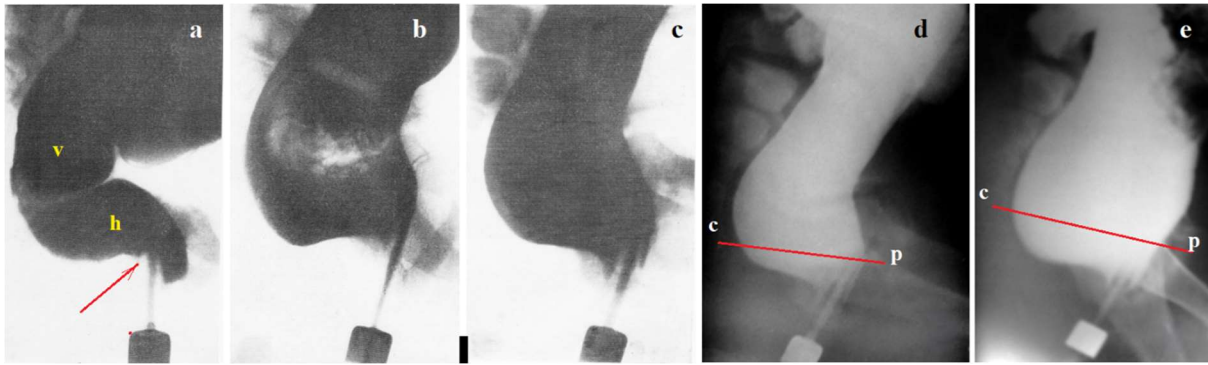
Lateral radiographs of the anorectal area in normal conditions (a) and with FM (b-e). (a) Two branches of the rectum are identified: vertical (v) and horizontal (h). The length of the anal canal is measured from the anorectal angle (arrow) to the radiopaque marker located near the anus. In the upper part of the anal canal in front of the enema tip, penetration of barium is determined, which is due to relaxation of the internal anal sphincter (IAS). The posterior wall of the anal canal at this level is pressed against the tip of the enema by the contracted PRM. The lower part of the anal canal is closed by contraction of the external anal sphincter (EAS). This is a retention reaction, which is the radiological manifestation of the rectoanal inhibitory reflex [15]. (b-c). Dilatation of the rectum is accompanied by the disappearance of the horizontal branch and the appearance of contrast material in the upper part of the anal canal behind the enema tip due to weakness of the PRM. (d-e). The expansion of the rectum is accompanied by a sharp shortening of the anal canal because of incompetent PRM.
